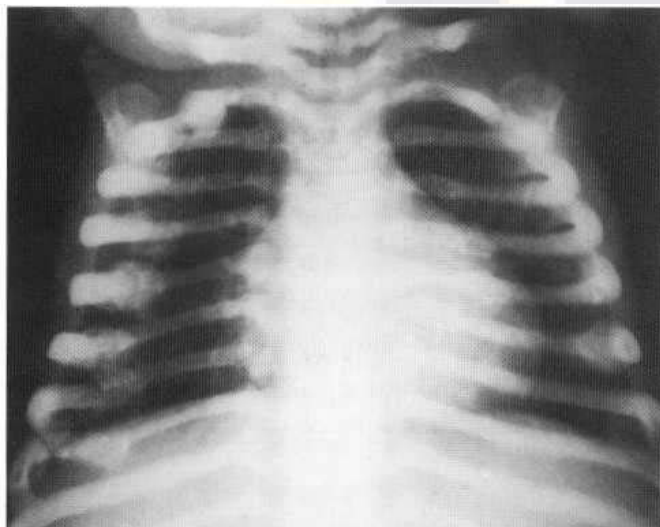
Non-accidental injury. The radiograph shows multiple rib fractures at different stages of healing, probably the result of repeated compression injuries to the thorax. The child was admitted with a recent skull fracture. (Courtesy of Dr D. J. Stoker and Institute of Orthopaedics.)
